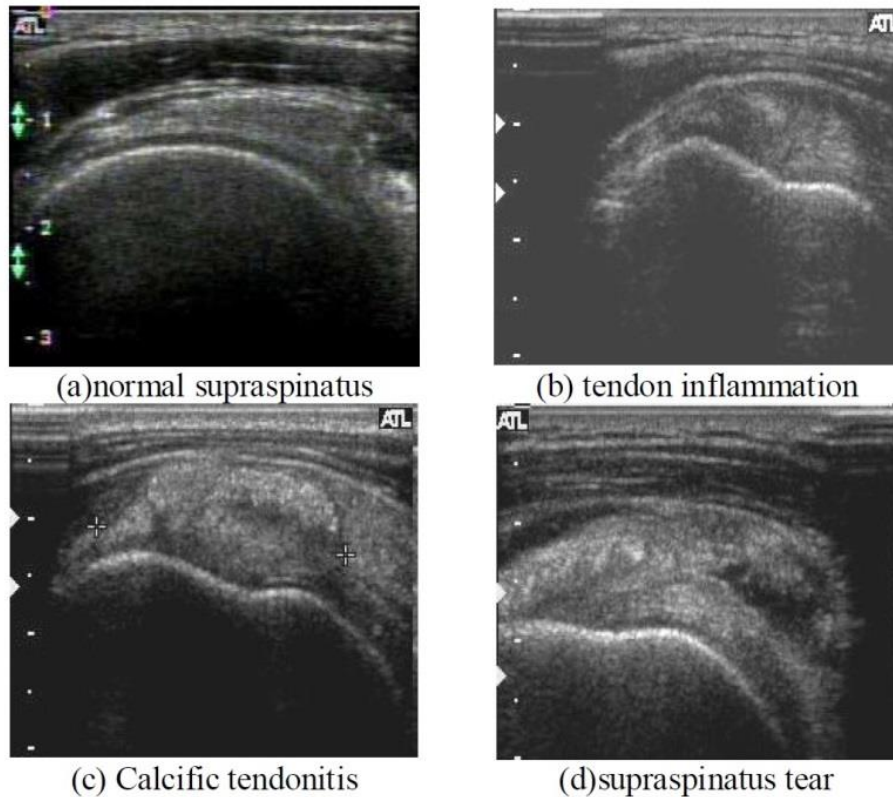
Samples of ultrasonic supraspinatus images. The image (a) is a normal case, image (b) is a sample of tendon inflammation. The images (c) and (d) are calcific tendonitis and tear, respectively (Adapted from [6] Horng et al.).
